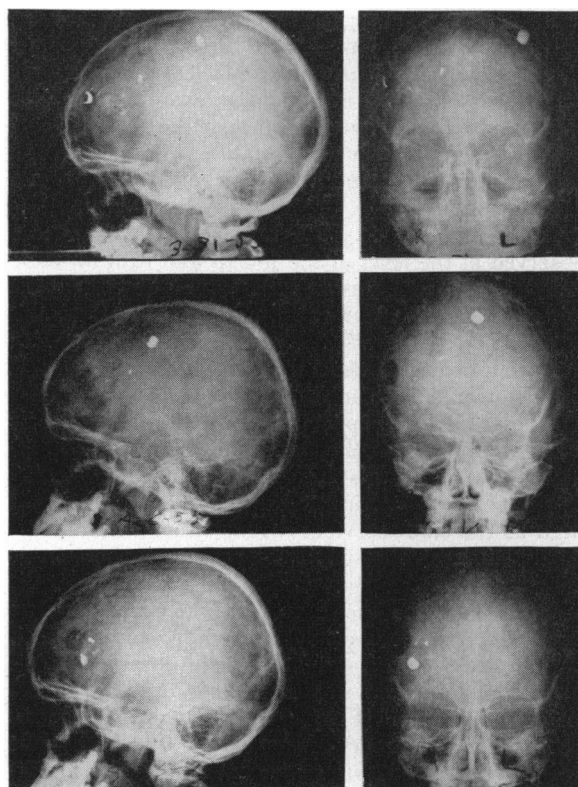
Top row: X-ray films on day of accident, showing fragments of lead along course of bullet from point of entry in right forehead to point at which major portion came to rest against skull on left side. Center: Films taken a week later, after fragments of slug had been removed, showing main body of bullet returned part way along course of penetration. Lower: Five weeks after the accident, bullet almost back to point of entry.
